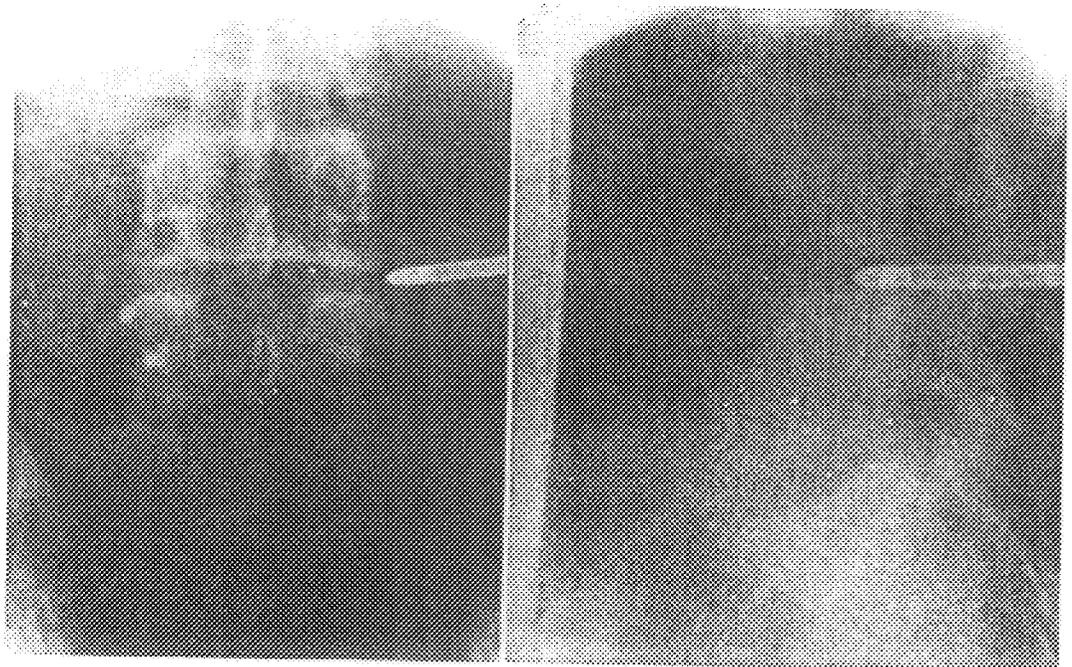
Roentgenographic documentation of position of trocar.
